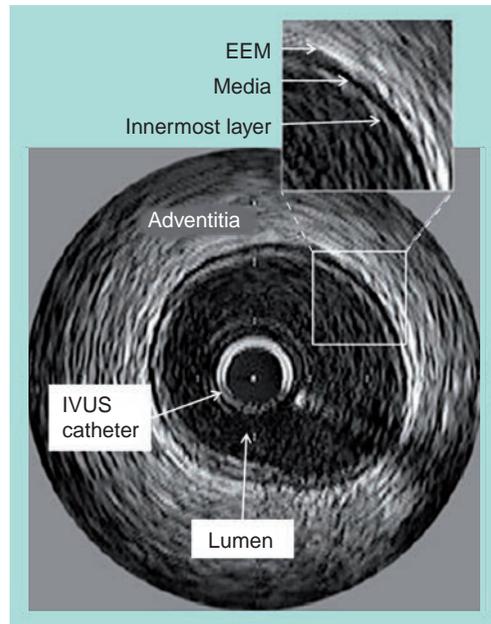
Normal coronary artery showing the innermost layer, the media layer and the external elastic membrane. The EEM is recognized as the interface between the echolucent muscular-media and the adventitia. EEM: External elastic membrane; IVUS: Intravascular ultrasound.
